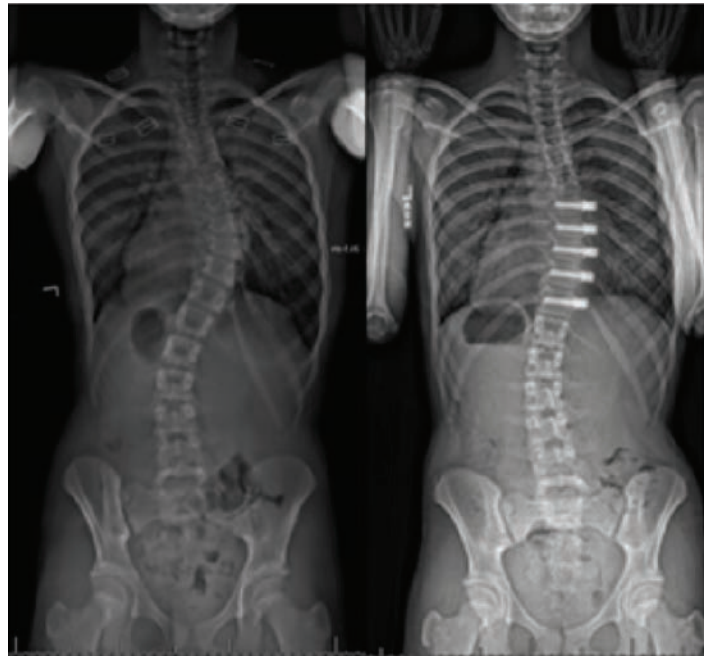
Pre- and post-standing radiographs showing instrumentation and initial correction.
